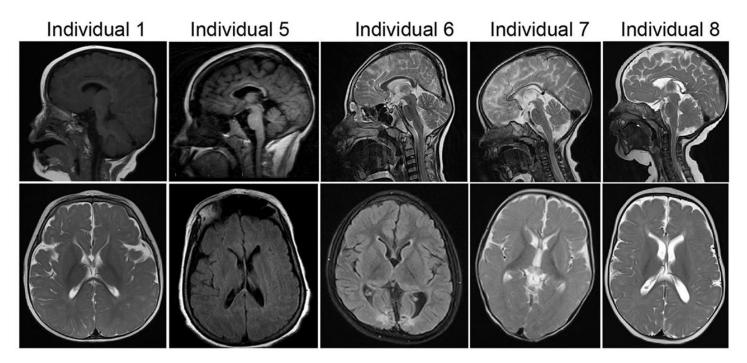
T₁- and T₂-weighted brain MRI images of Individuals 1 and 5-8 in sagittal and axial planes. Note the various degrees of cerebral atrophy, cerebellar hypoplasia, thin corpus callosum, and white matter abnormalities.
